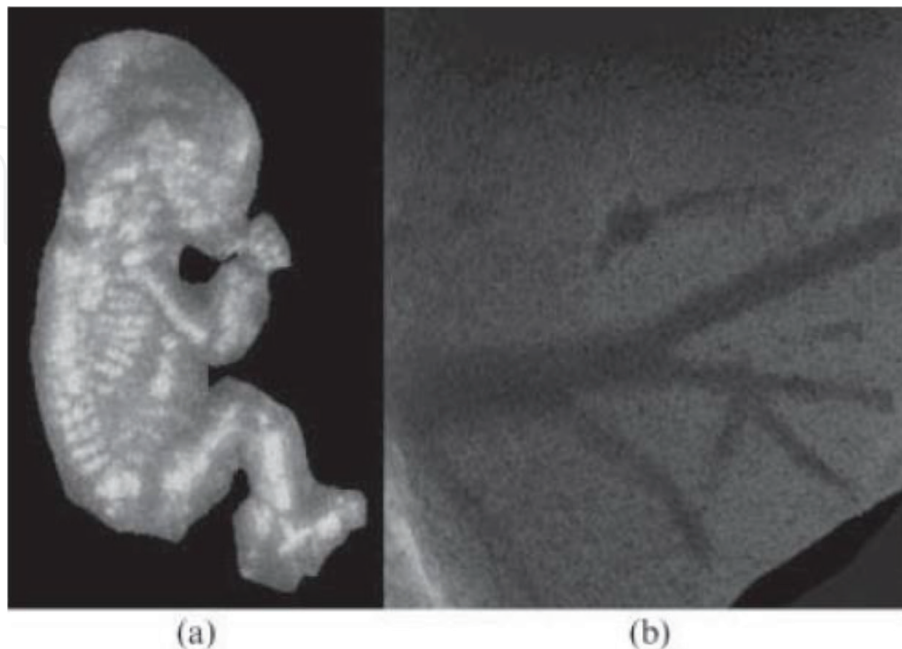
The different volumes rendering visualization of 3D ultrasound imaging system approaches, where (a) shows the maximum intensity projection of a fetus and (b) shows the minimum intensity projection of blood vessels in the liver [30].
